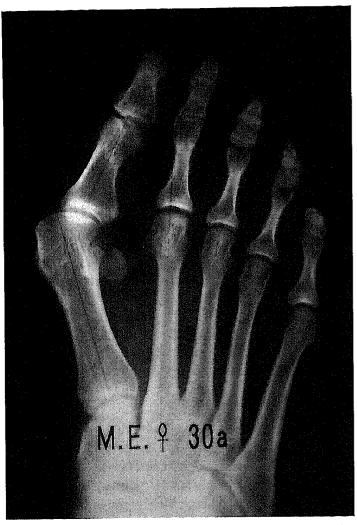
Patient 9. This 30-year-old woman had a preoperative roentgenogram showing an angle of 42° between the phalanx and the metatarsal bone of the great toe and an angle of 20° between the first and second metatarsals.
